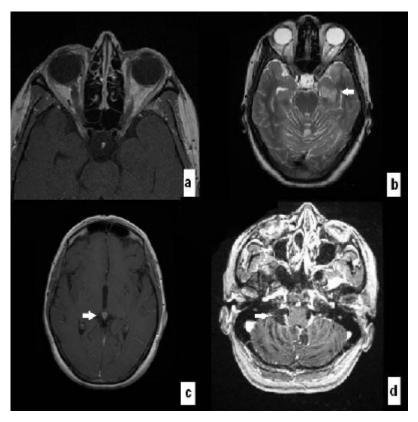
Cranial MRI. (a) bilateral optik nerve tumors (b) a low grade glial tumor on the left temporal lobe (c) a pinealoma (d) a vestibular schwannoma on the right (*arrows*).
